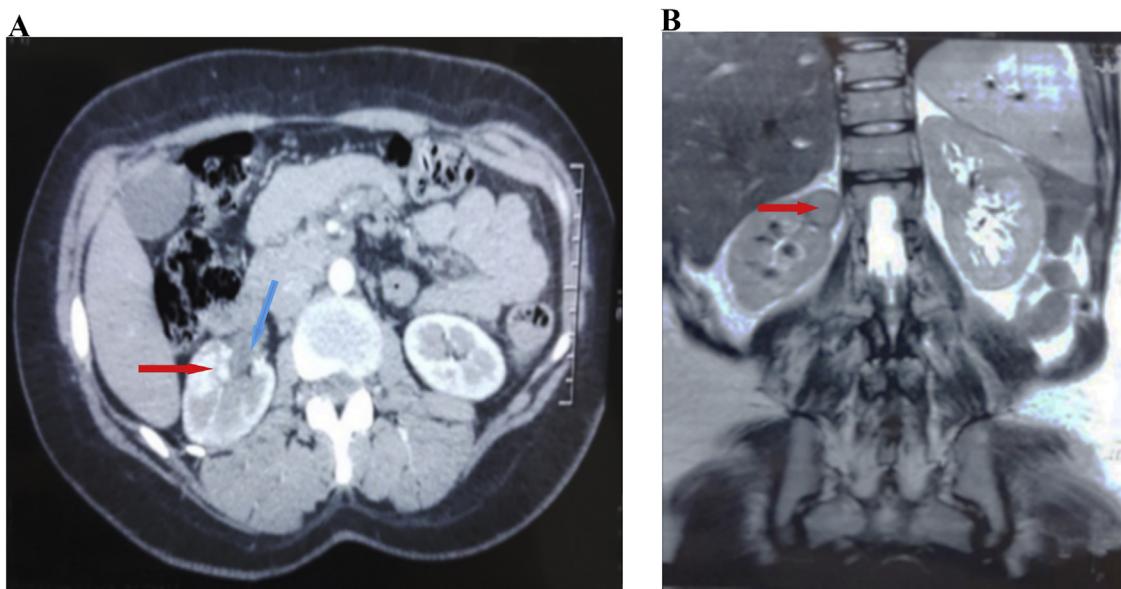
(A) Computed Tomographic Urogram with Intravenous Contrast Enhancement and dilation of the renal pelvis (blue arrow), (B) MRI images showing right upper polar renal mass (red arrow).
